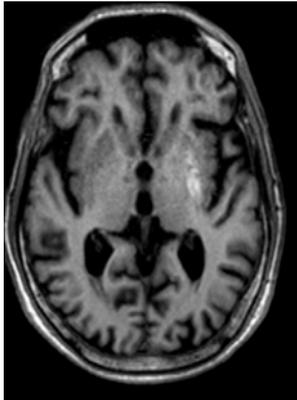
MRI brain showing T1 hyperintense lesion in left putamen in an 82 years male with right hemichorea hemiballismus . Source : department of radiodiagnosis DSMC ,Siruvachur
